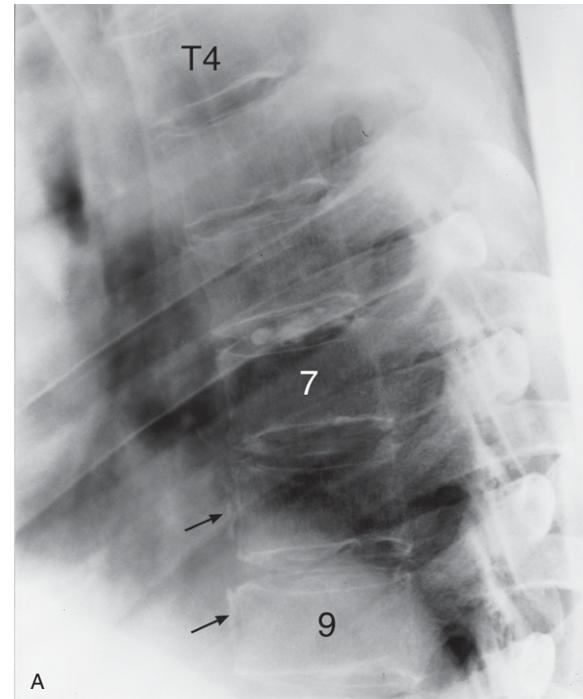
(A) Thoracic spine (T4–T9) lateral plain X-ray image showing the ‘idiopathic calcification in the T6–7 disc with early calcification appearing in the T7–8 disc’. Also note the slight calcification probably located within the anterior longitudinal ligament (arrows). T4 = fourth thoracic vertebra; T6 = sixth thoracic vertebra; T9 = ninth thoracic vertebra.
